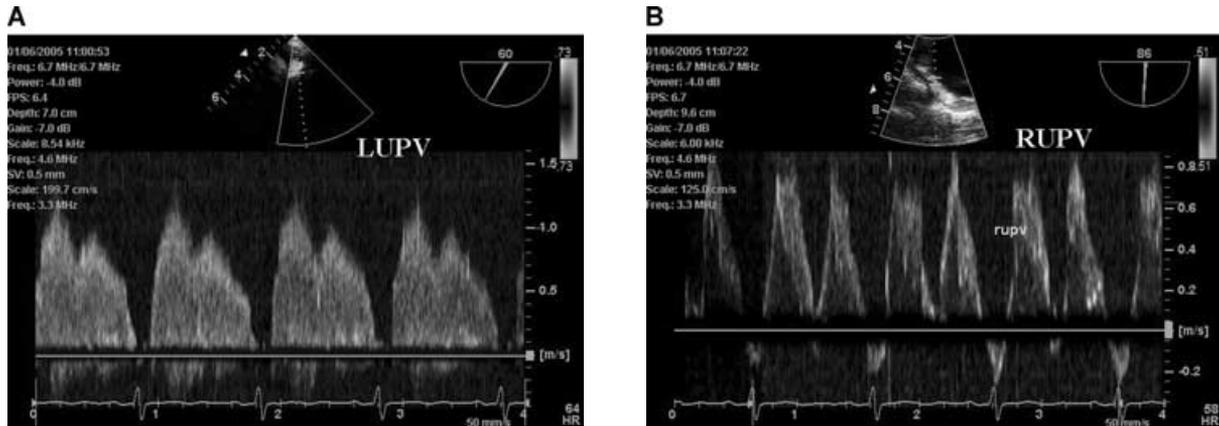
Transesophageal echocardiography (TEE) with pulsed-wave Doppler of the pulmonary veins. Sampling was performed within 1 cm of the orifice of the pulmonary vein evaluated. (A) Left upper pulmonary vein flow demonstrated a relatively high velocity (1 m/sec), with a prolonged deceleration slope of both systolic and diastolic waves. In addition, the atrial reversal was not present. These findings are consistent with extrinsic compression of that pulmonary vein. (B) Right upper pulmonary vein flow (RUPV) revealed flow velocities in the range normally found.
